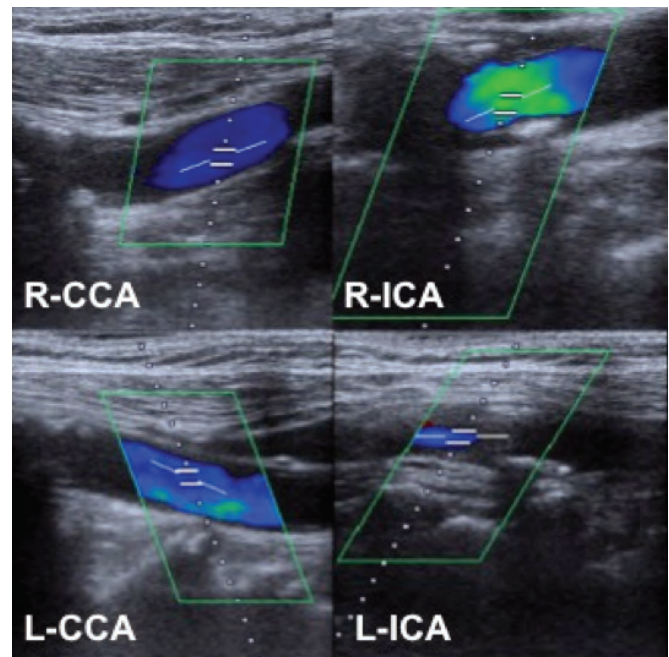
Doppler Ultrasound: Left Internal Carotid artery stenosis (greater than 70% - NASCET criteria).
